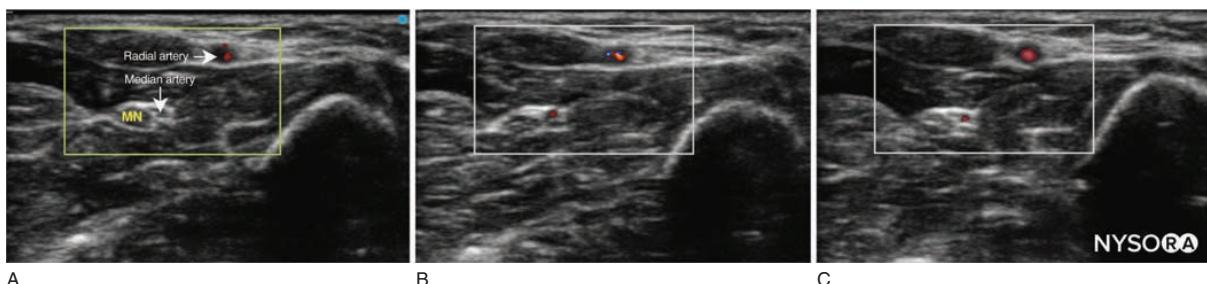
Examples of Doppler imaging of the small median artery: (A) high-flow color Doppler, (B) low-flow color Doppler, and (C) power Doppler.
